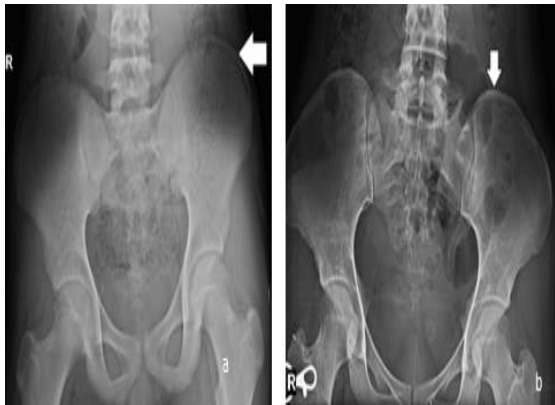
X-ray pelvic antero-posterior view (a) 15 years old male and (b) 20 years old female with Grade II ossification of iliac apophyseal cartilage (white arrows).
